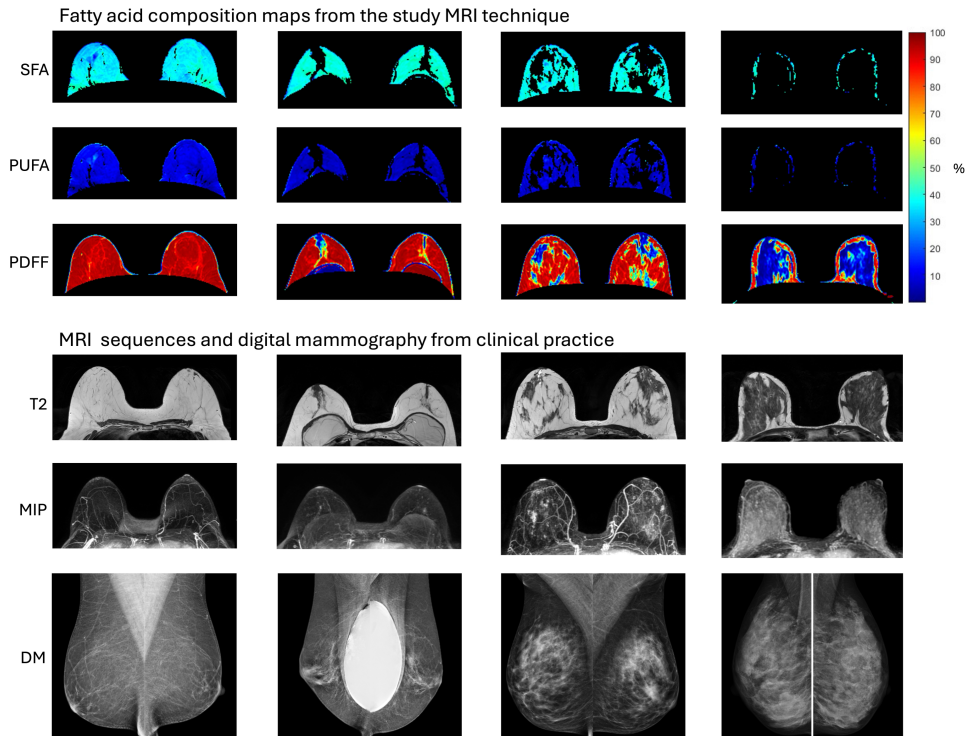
Fatty acid maps, clinical MRI, and mammography from four women in paper IV
